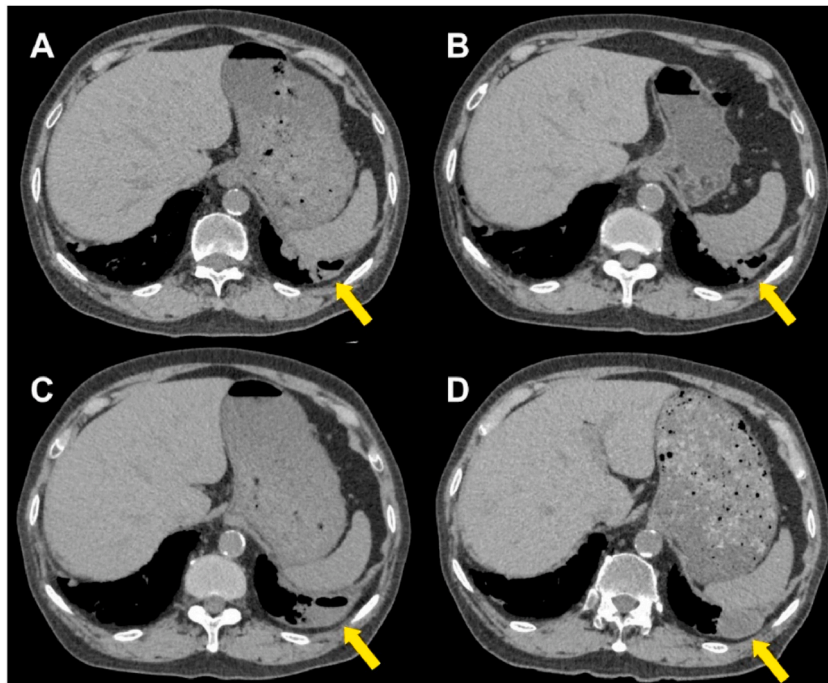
(A–D) Plain chest computed tomography. These images show the nodule (arrow) in the left lower lobe in the order of time series. A: One year previous from the surgery. B: Eleven months previous from the surgery. C: Five months previous from the surgery. D: Three and a half months previous from the surgery.
